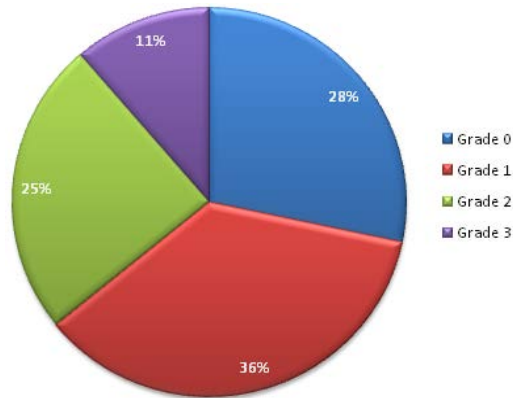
Distribution of different classes in placental sonograms
